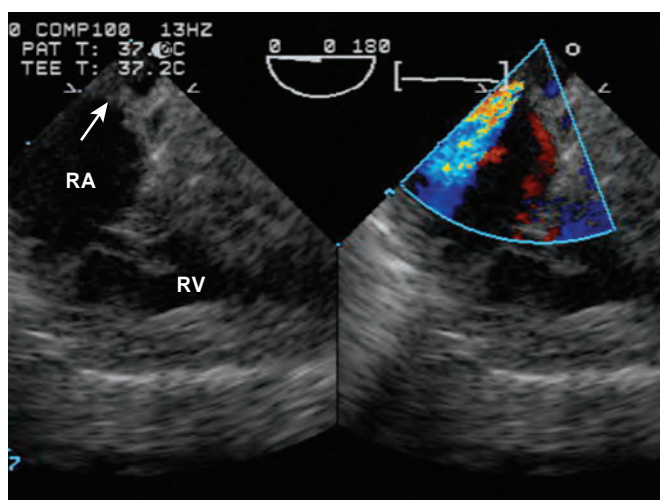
Side-by-side images in 2D (left image) and with color flow Doppler (right image). In the 2D image there is a possible inferior residual atrial septal defect (ASD; arrow). With color flow Doppler the residual ASD is clearly appreciated. The orange speckling superimposed on the blue color confirms high-velocity flow. RA, Right atrium; RV, right ventricle.
